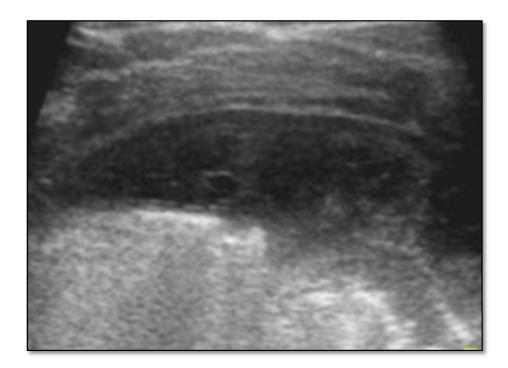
Ultrasound image showing echogenic effusion in a patient with empyema.
